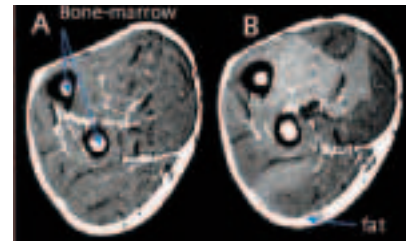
Typical T2-weighted ^1H MR images recorded on a Siemens Vision Plus system (extremity coil) representing transverse sections of the forearm recorded at rest (A) and after a finger flexions exercise (B). Areas with a higher contrast on the image B indicate the activated muscles during exercise.
